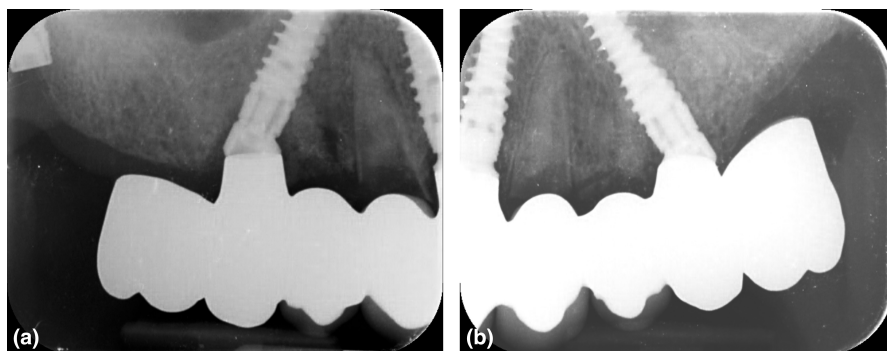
(a, b) Periapical radiographs to assess the correct fit of the ISZ-FDP in the patient's mouth during the Sheffield one-screw test. ISZ-FDP, implant-supported screw-retained zirconia-based complete-arch fixed-dental prostheses.
